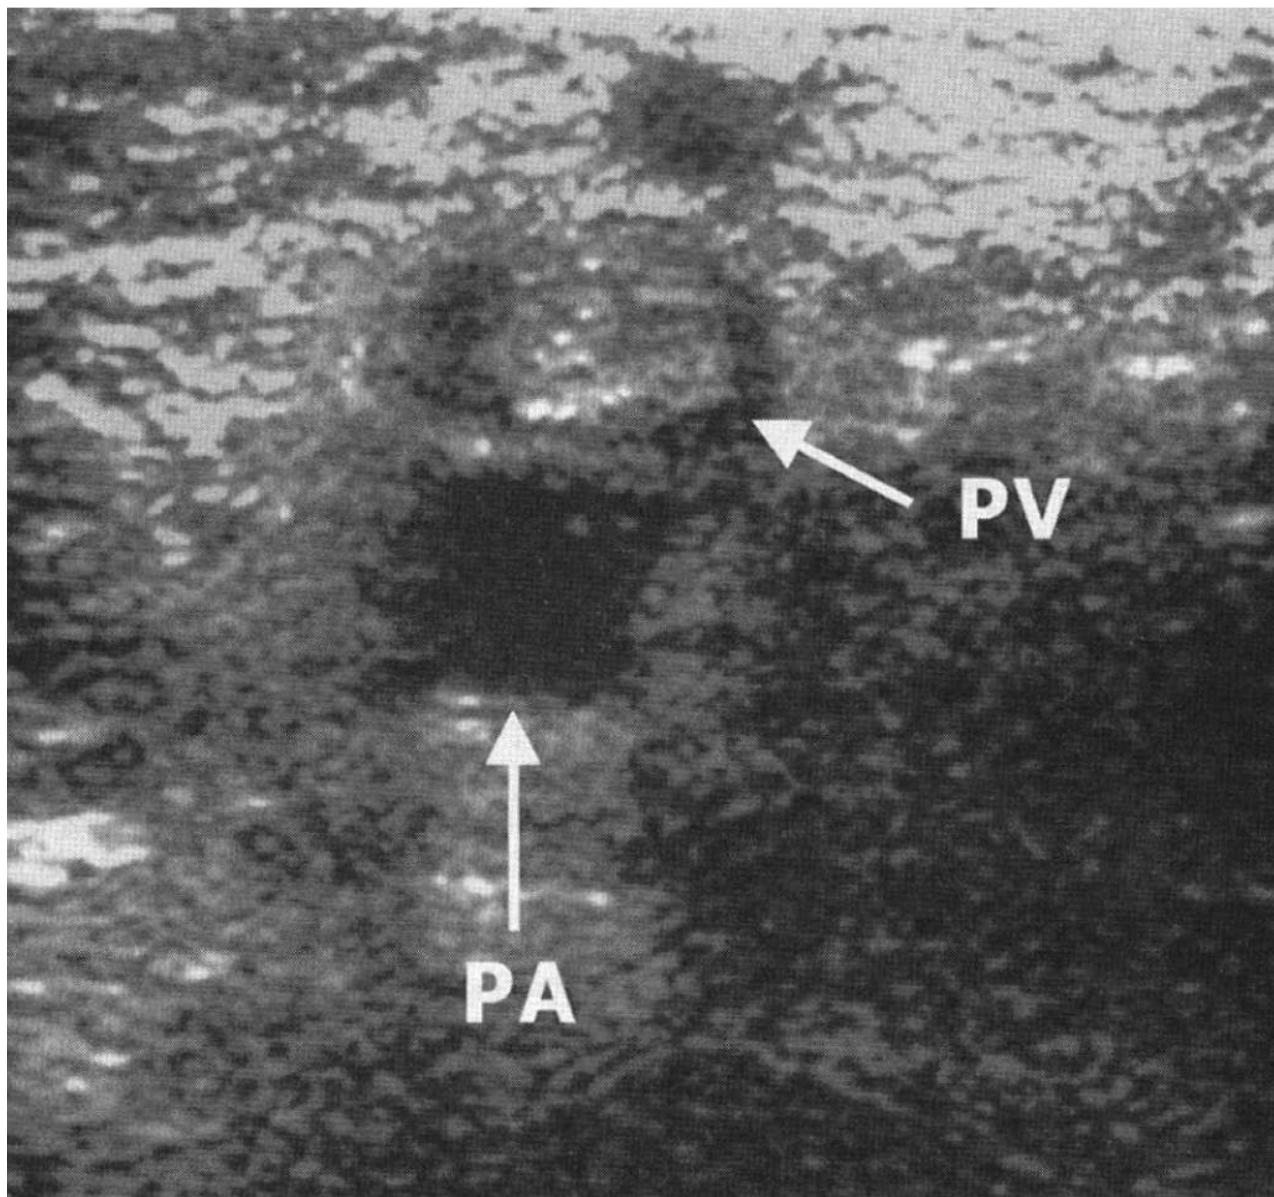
An echogenic thrombus can be seen within the popliteal vein. PV, popliteal vein; PA, popliteal artery. (Reproduced with permission from Ma OJ, Mateer, JR, & Blaivas M: *Emergency Ultrasound*, 2nd edition. New York: McGraw-Hill Publishing; 2007.)
